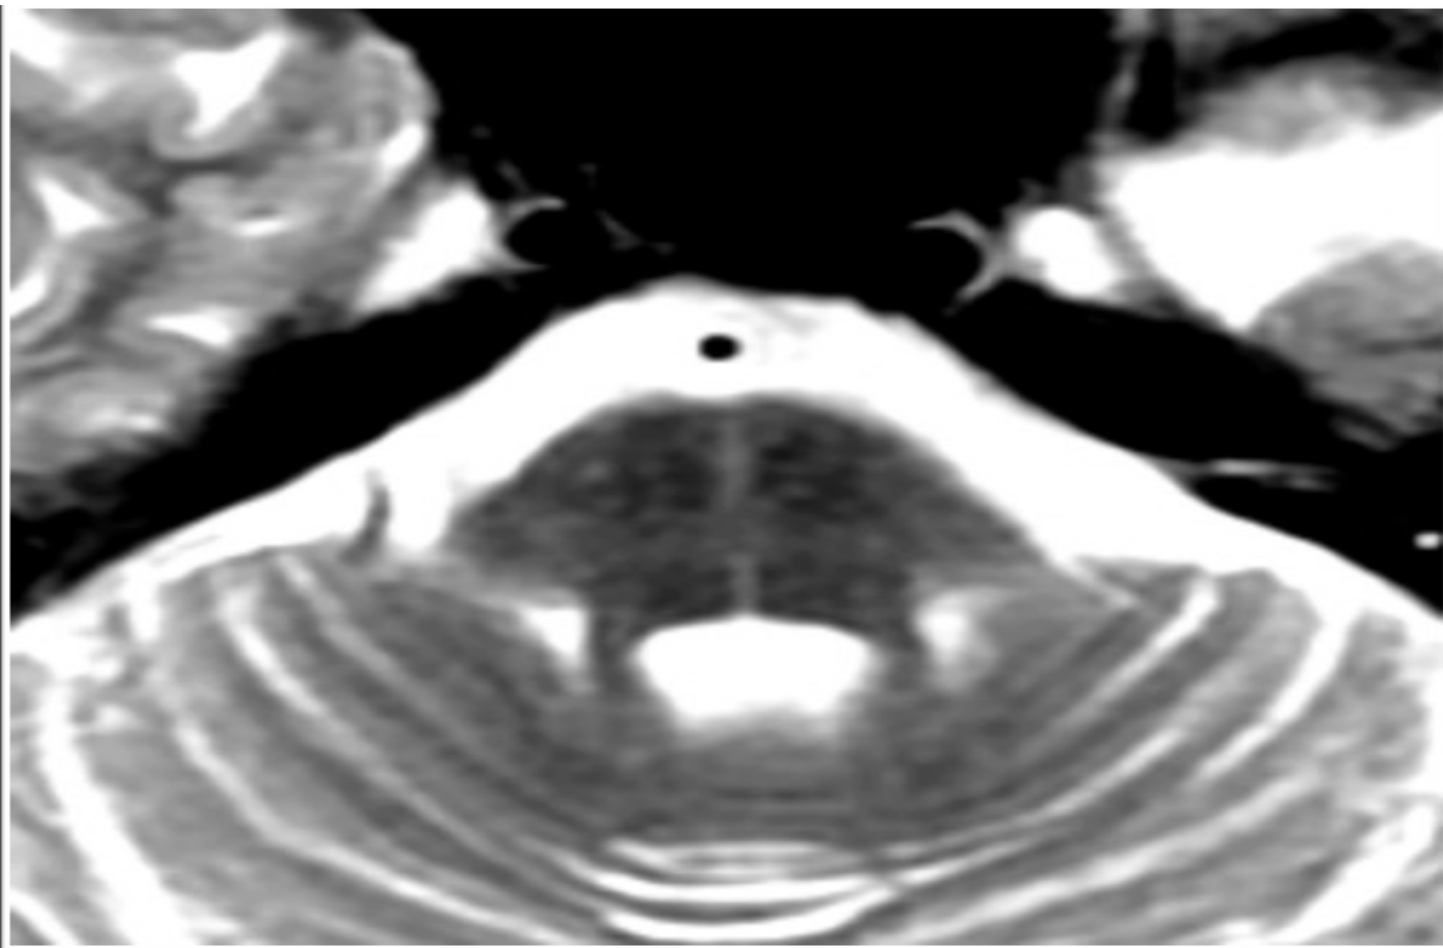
"hot cross bun" sign seen in pons on T2 MRI. (c)
